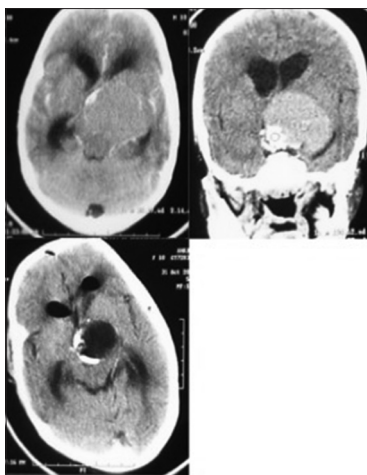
Top row images 1 and 2 – Computed tomography axial and coronal sections show large cystic suprasellar tumor with calcification. Bottom row image - catheter in situ in cystic cavity with reduction in cyst volume
